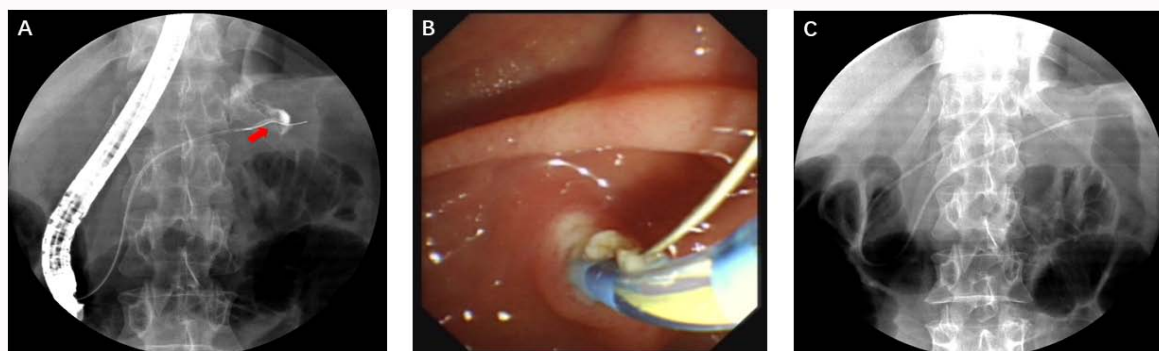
A. The pancreatic duct is visualized under X-ray, the contrast agent leakage is seen in the tail of the pancreas. B. After incising the duodenal papillary, some stones of the pancreatic canal can be seen. C. The nasopancreatic drainage is inserted into pancreatic tail which can drain the pancreatic fluid.
